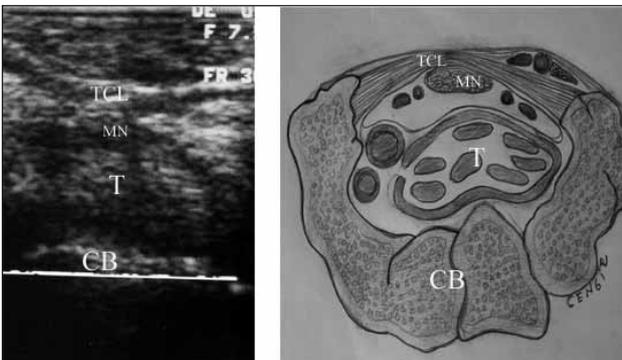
A. This figure an example for carpal tunnel ultrasonography (TCL: Transverse carpal ligament, MN: Median nerve, T: Tendons, CB: Carpal bones).
